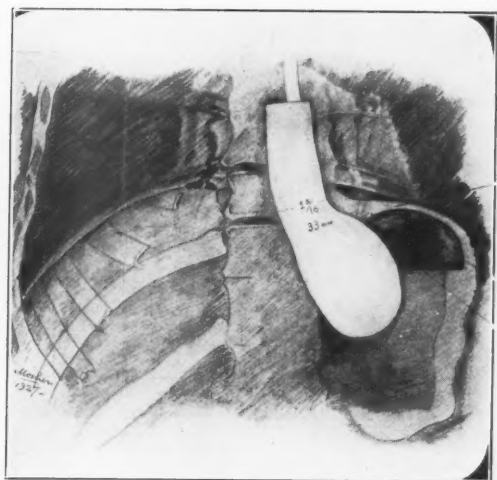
Adult, male; 30 years. Normal esophagus. Retouched tracing from X-ray film. The diagnostic barium bougie is shown in place. It gives the normal transverse diameter of the terminal portion of the esophagus to be 33 mm. The anteroposterior diameter is practically the same.
